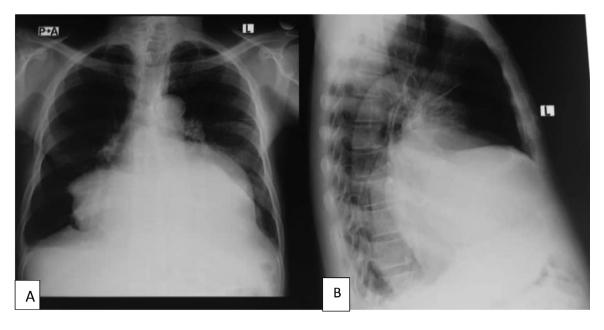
(A and B) Posterior-anterior (PA) and lateral chest radiograph showing a large anterior mediastinal lesion overlying the cardiac silhouette.
